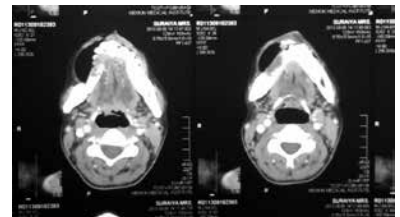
CT scan showing a radiolucent multilocular area in lower left mandible causing asymmetry.
